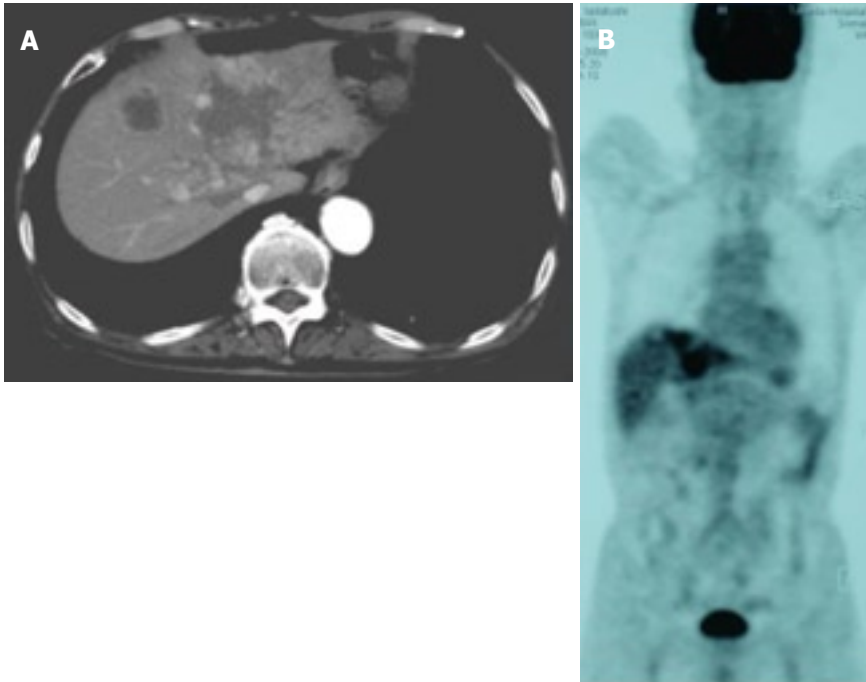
Images after the end of 7 cycles of chemotherapy. A: CE-CT showed a reduction in the size of a huge tumor seen in the medial segment; B: PET-CT revealed abnormal uptake only in the tumors in the medial segment, and no uptake was observed in tumors from the right lobe and the LNs in the liver hilus and para-aorta.
